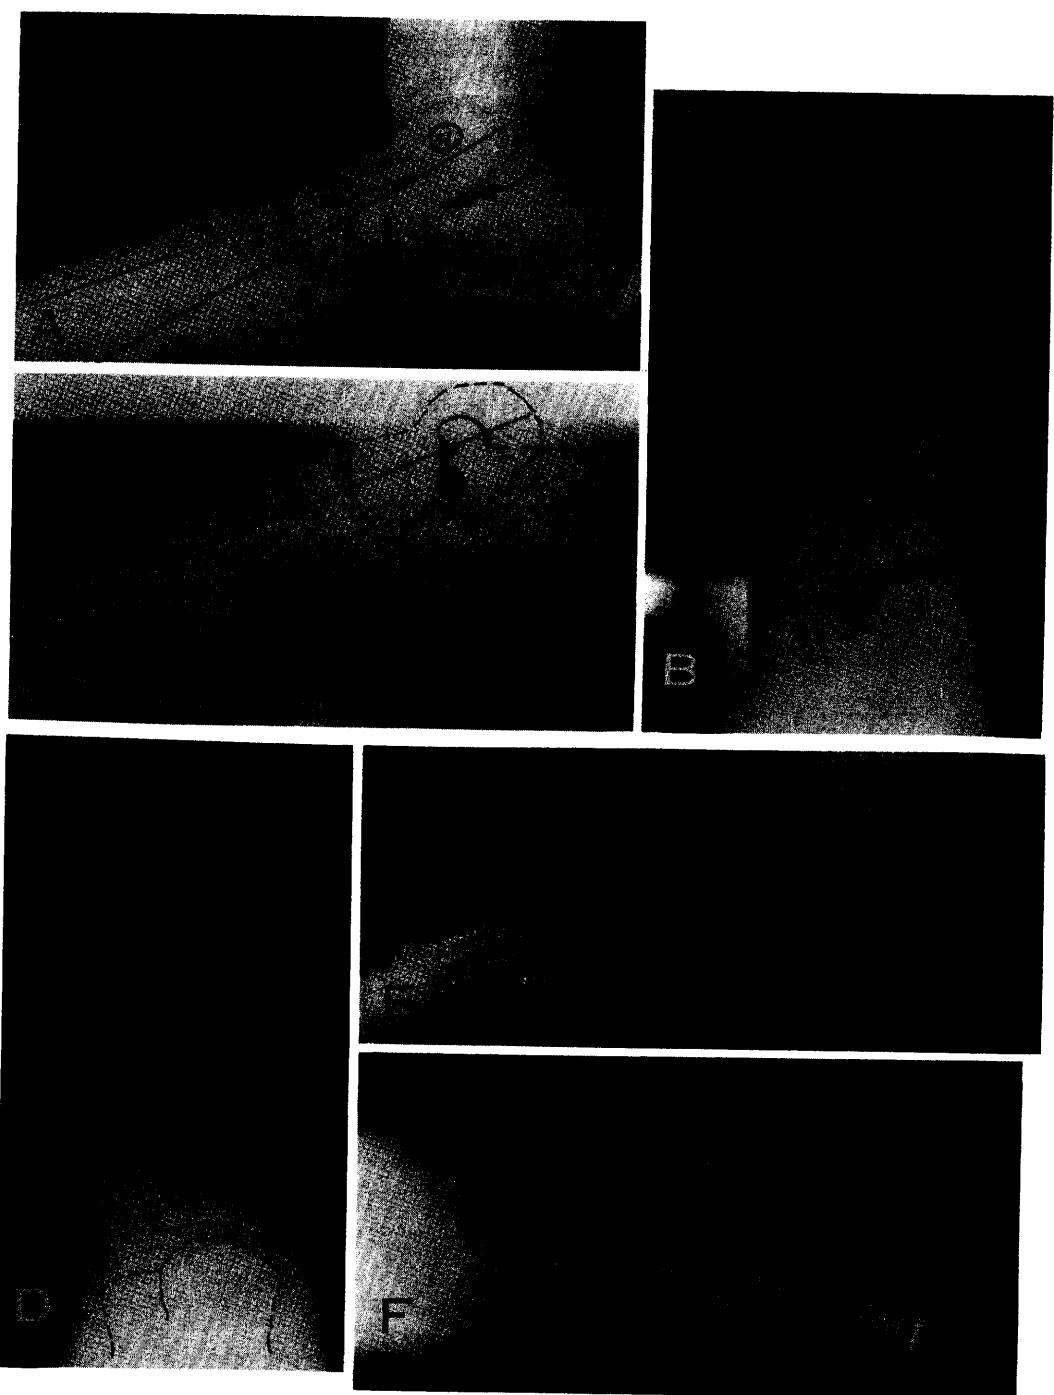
Operative x-rays for lateral arthroereisis of the subtalar joint. A, preoperative lateral x-ray. (Note changes on the lateral x-ray: obliteration of the sinus tarsi, creation of a pseudo sinus tarsi, anterior broken cyma line, low calcaneal inclination angle, and increase in talar declination angle.) B, dorsoplantar preoperative roentgenogram. (Note break in the dorsal cyma line and subluxatory changes at Chopart's joint. Also note that less than one-half of the talus articulates with the navicular.) C, postoperative lateral arthroereisis of the subtalar joint. (Note realignment and reduction of the talar declination angle, opening of the sinus tarsi, increase in calcaneal inclination angle and placement of the position of the Silastic implant.)
